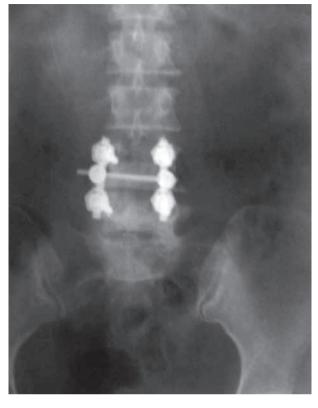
Follow up radiograph anteroposterior view of instrumentation and ALIF in L4-5 listhesis.
